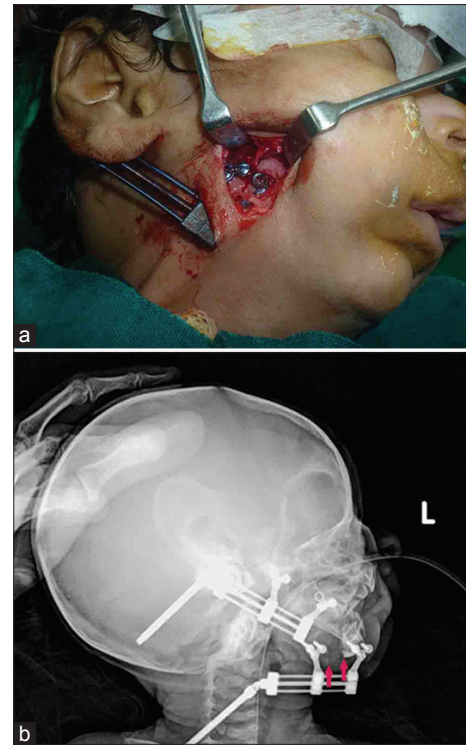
(a) Intraoperative photographs showing fixation of the distraction device onto the mandible; (b) radiograph during course of distraction with the red arrows demonstrating the bone margins, with new bone formation in the intervening space
